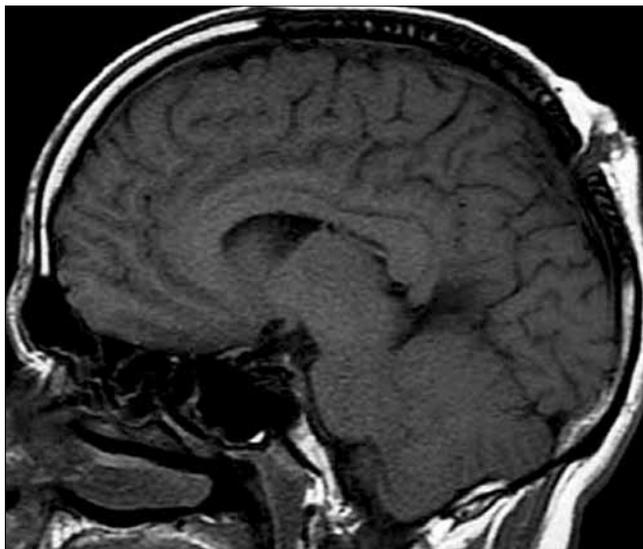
Sagittal T1-weighted magnetic resonance image: A parietal-located calvarial defect and a subscalp lesion.
